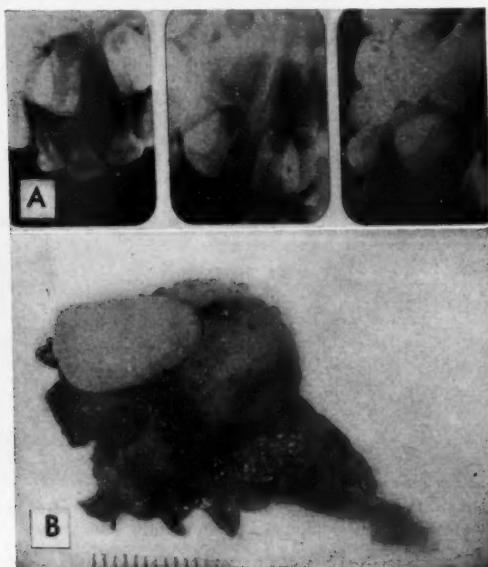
Cyst involving the permanent left central incisor. A, The deciduous left central and lateral incisors are intruded and the tooth bud of the permanent central incisor has become involved. B, Photograph of cyst shown in roentgenogram (A).
